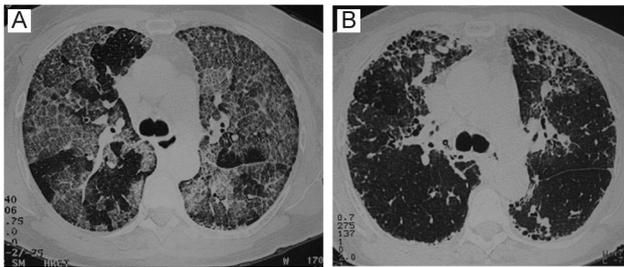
High-resolution computed tomograms from patient 1. A: At diagnosis of pulmonary alveolar proteinosis (1999). B: At diagnosis of diffuse interstitial fibrosis (2006).
